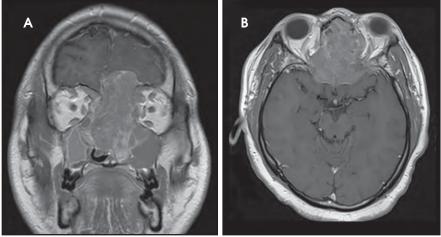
Coronal (A) and axial (B) T1-weighted facial magnetic resonance (MR) images demonstrate a large mass lesion involving nasal cavity with intracranial extension superiorly and extensive involvement of the sphenoid sinuses and orbits bilaterally.
